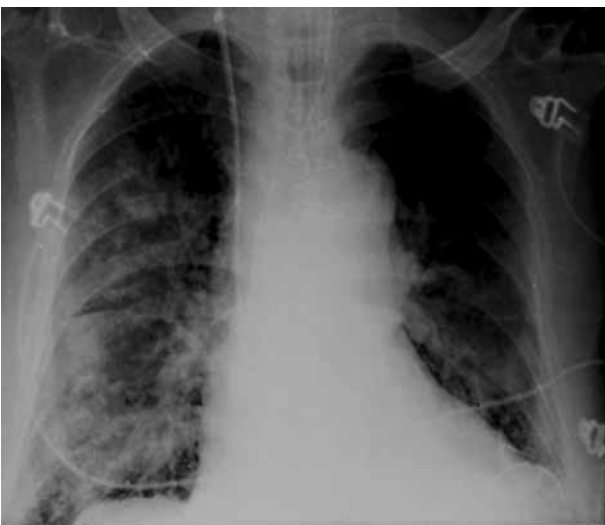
Chest radiograph performed 6 hours after surgery showing marked decrease of left lung edema.
